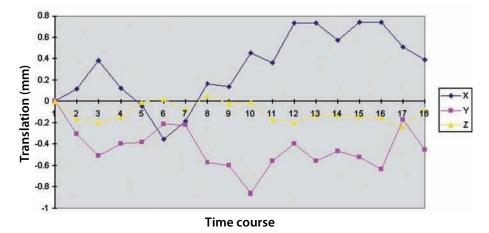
Graph of head movement occurring during a functional MRI scan. The graph shows translations in the x, y and z planes during the collection of 18 dynamic images over a period of just under 2 min
